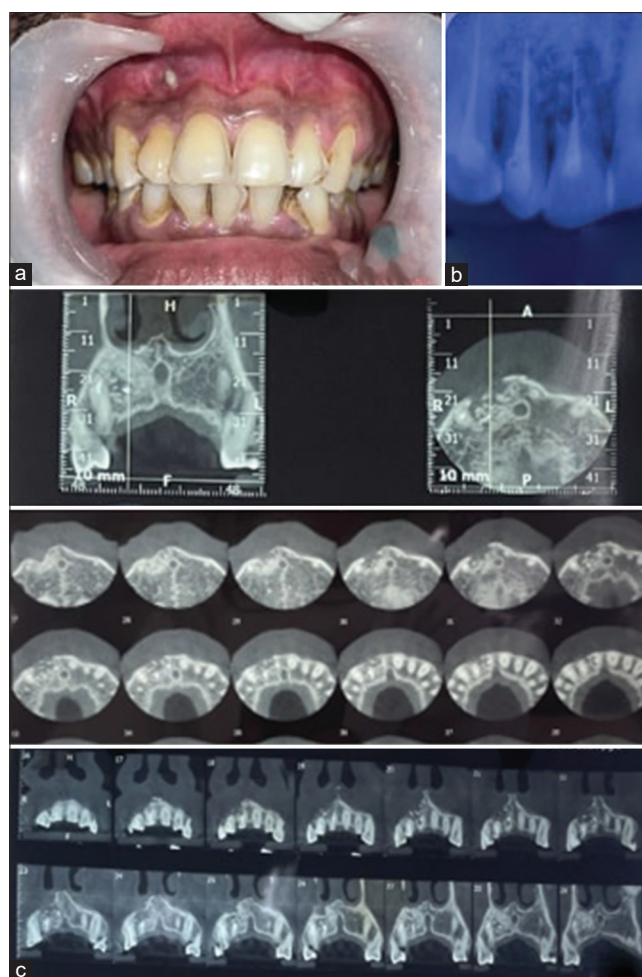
(a) Preoperative Clinical image showing sinus opening, (b) Pre-operative IOPA with mixed radiolucency and radiodensities, (c) CBCT showing full extent of the lesion
